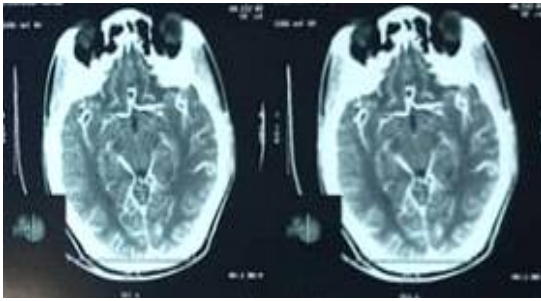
Computed Tomography Angiogram - Showing posterior communicating artery (PCOM) aneurysm
